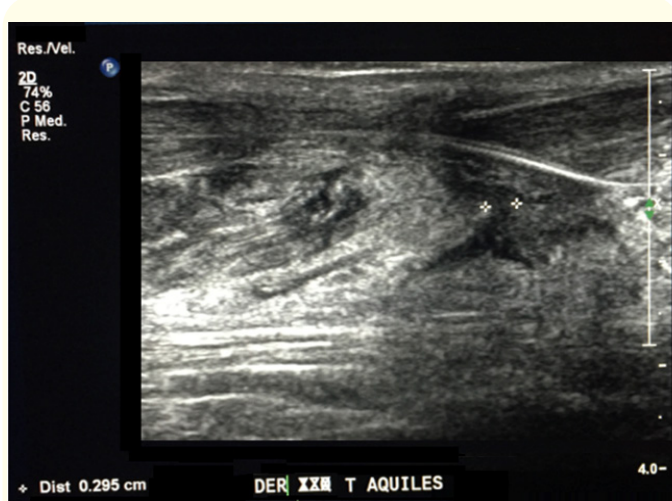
Measurement of the loss of coping of the ends under ultrasound vision.
